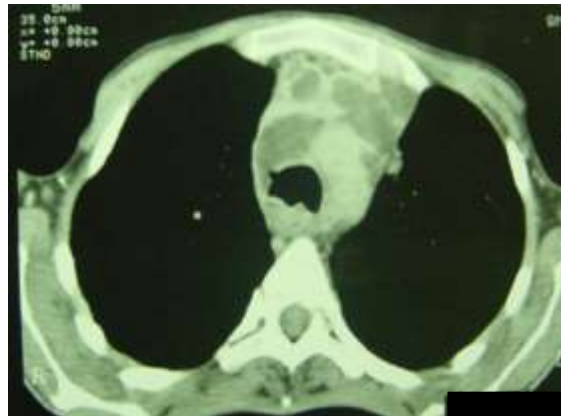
Computed tomography of thorax reveals Multiple caseating mediastinal lymphnodes with irregular tracheal outline.
